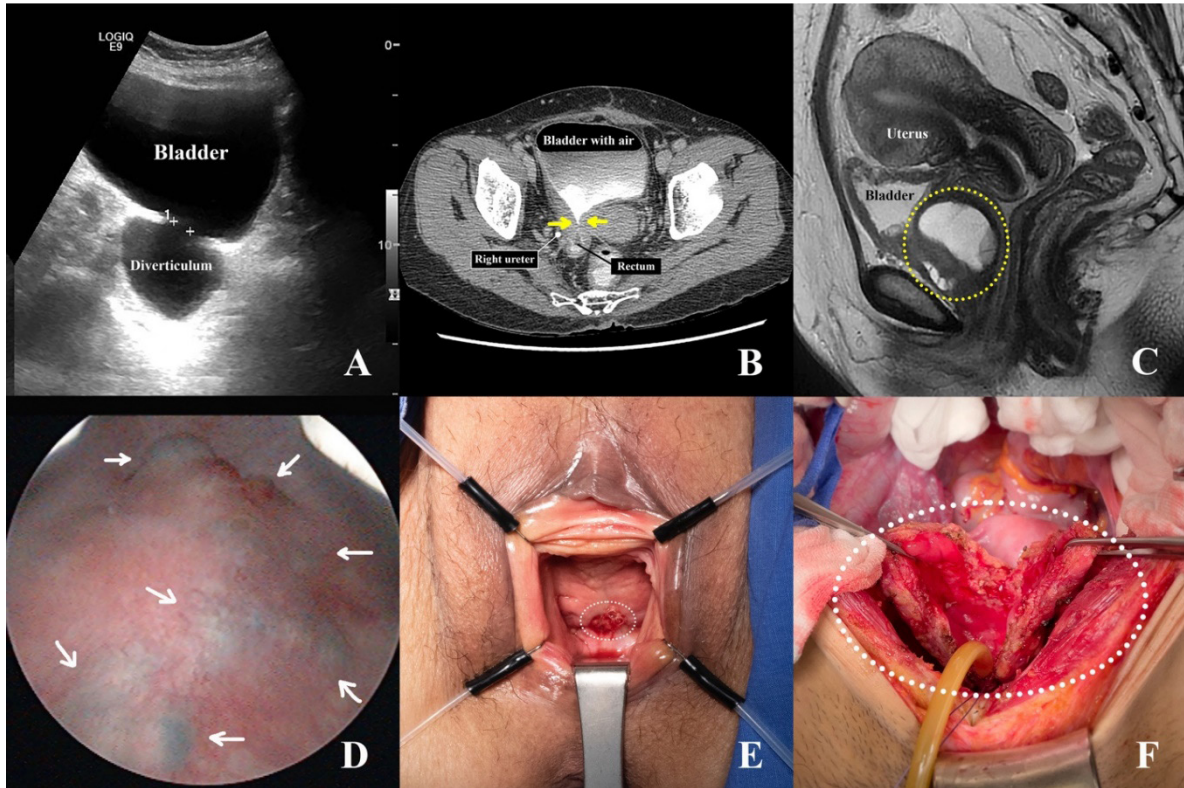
(A) Ultrasonography demonstrates a bladder diverticulum, an outpouching lesion arising from the posterior bladder wall. (B) Computed tomography demonstrates a rectovesical fistula, occurring after low anterior resection for rectal cancer. (Yellow arrows) (C) Magnetic resonance imaging shows a urethral diverticulum, an outpouching lesion arising from and wrapping around the urethra. (Yellow circle) (D) Cystoscopy demonstrated endometriosis, involved posterior bladder wall, seen as tortuous dark-blue lesions. (White arrows) (E) Vaginal examination demonstrated mesh extrusion (white circle) after pelvic organ prolapse repair, causing of vaginal infection and clinical cystitis-like symptoms. (F) Intraoperative findings from abdominal cystostomy demonstrated a severely contracted and inflamed bladder wall (white circle) from ketamine abuse.
